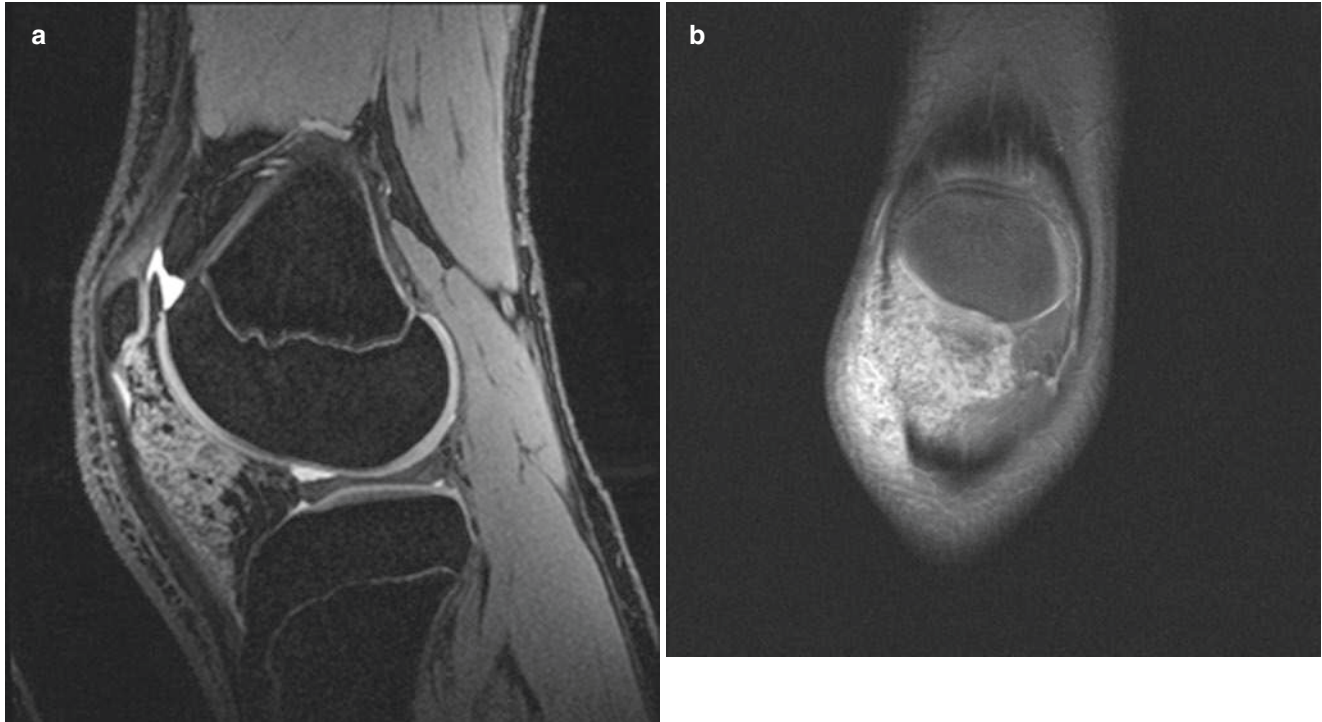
Synovial venous malformation in a 13-year old girl with episodes of joint swelling. (a) Sagittal 3D gradient echo (DESS) image shows a multilobular mass high SI mass occupying a significant portion of Hoffa's fat pad and abutting the articular cartilage. Small round low SI structures correspond to phleboliths or small thrombi. (b) Coronal gadolinium-enhanced T1-weighted image shows diffuse enhancement of the mass indicating that it is a venous malformation
